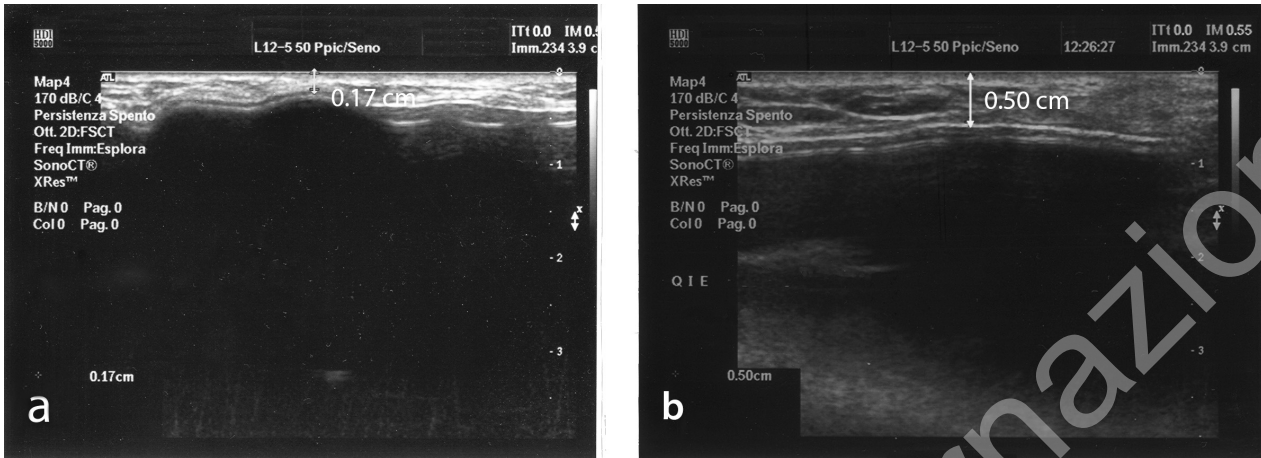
Ultrasound images: lower outer quadrant (LOQ) of the right breast a) prior to treatment and b) 3 months after first lipofilling session. The ultrasound examinations were performed by the same operator, using ATL Ultrasound HDI-5000.
